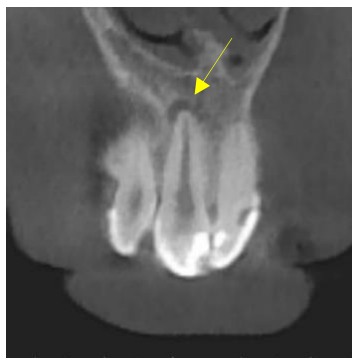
Coronal CBCT cross section depicting apical periodontitis associated with tooth #8
